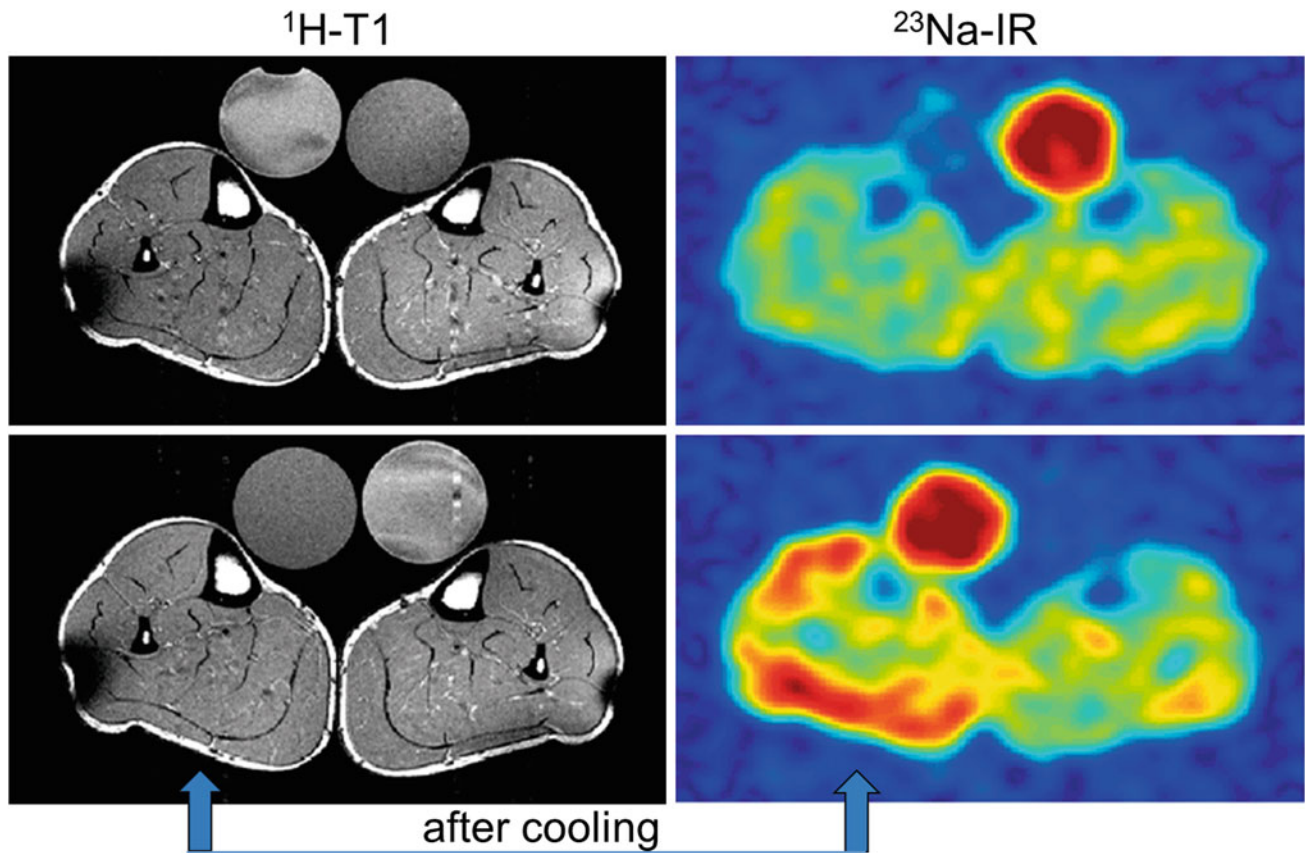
^1H -MR and ^{23}Na -MR images of a PC patient before and after cooling of the lower leg (arrow). While the T1-weighted ^1H -MR signal is unaltered, the ^{23}Na inversion recovery (Na-IR) signal is
